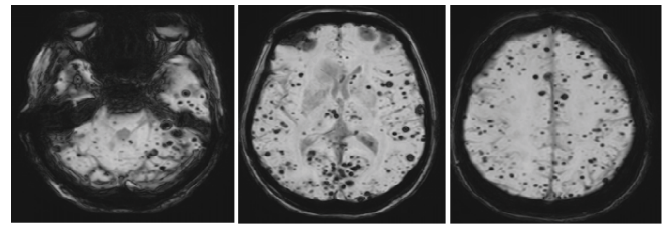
MRI demonstrates numerous lobar, cortical-subcortical, and infratentorial microhemorrhages with a non-hypertensive distribution, consistent with cerebral amyloid angiopathy (CAA).
